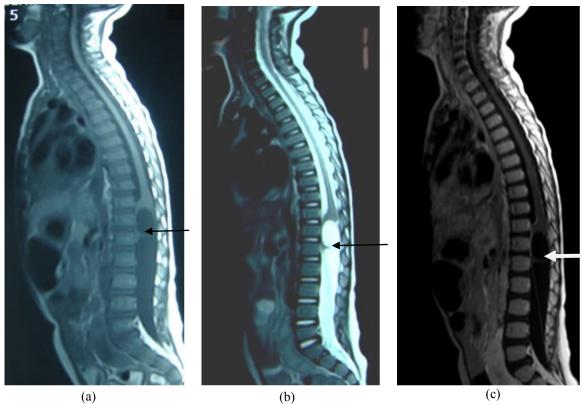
(a): Sagittal T1 WI of spine MRI; a hypointense well-defined, expansile intramedullary lesion at the conus medullaris (arrow). (b): The lesion turn into hyperintense on T2 WI MRI (arrow). (c): Sagittal T1W1 after Gadolinium administration: The lesion does not show any enhancement (see arrow)
